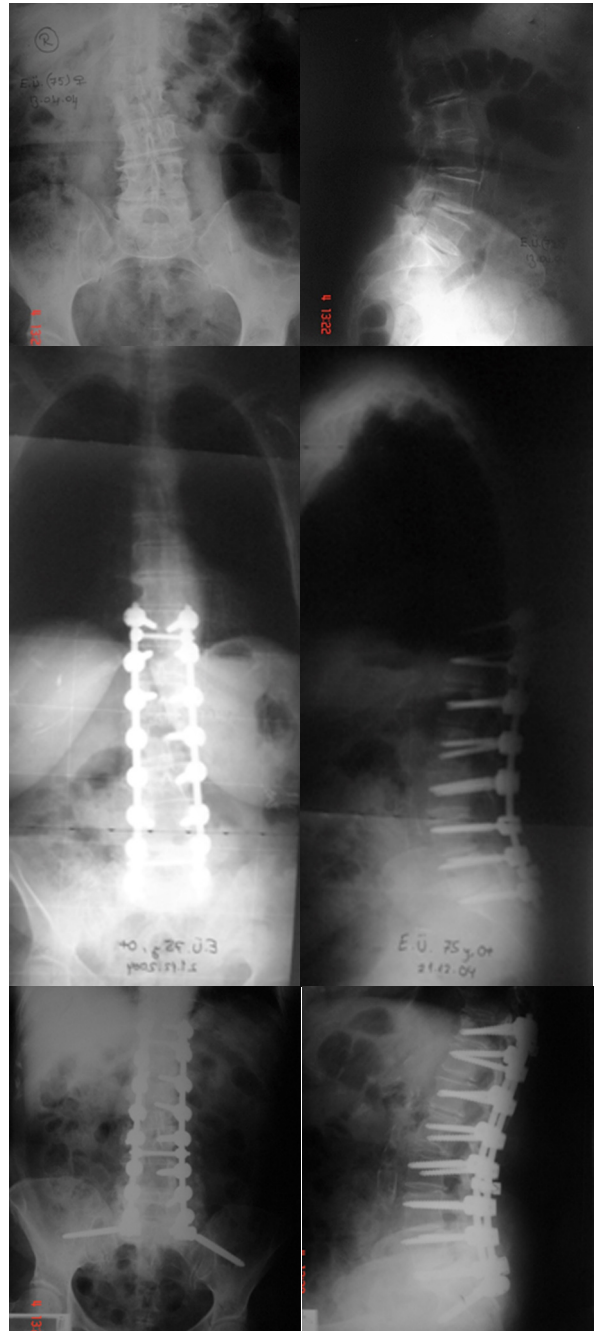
A 75 years old female patient with degenerative lumbar vertebrae, preoperative x-rays show (a, b) degeneration at L5-S1 level. Patient was treated with posterior instrumentation with T11-S1 posterior fusion (c, d). In the follow ups due to screw loosening and pain complaints revision surgery was performed (e, f).
